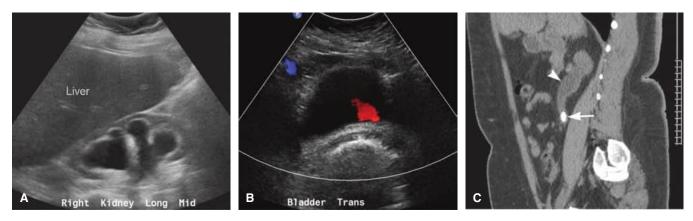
A. Sonographic image of the right upper quadrant demonstrates severe hydronephrosis and thinned echogenic renal parenchyma. B. Application of color Doppler during sonography of the bladder reveals a urine jet (*red streak*) from the left ureteral orifice. No flow was noted from the right orifice during observation. C. Sagittal CT image shows an obstructing stone in the mid right ureter (*arrow*) and hydroure-teronephrosis (*arrow head*).
